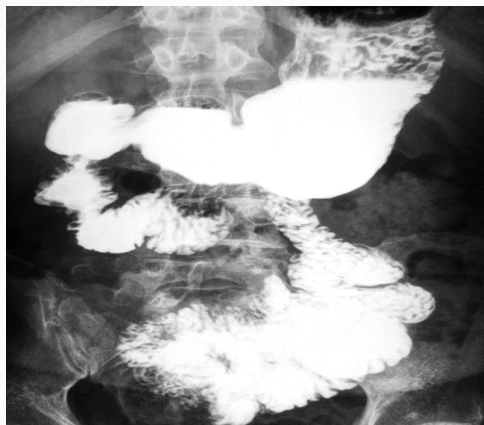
Postoperative day 7 upper gastrointestinal X-ray series. The arrow shows the pedicled ileal flap. The passage through the “new duodenum” was well maintained without stenosis or leakage.
